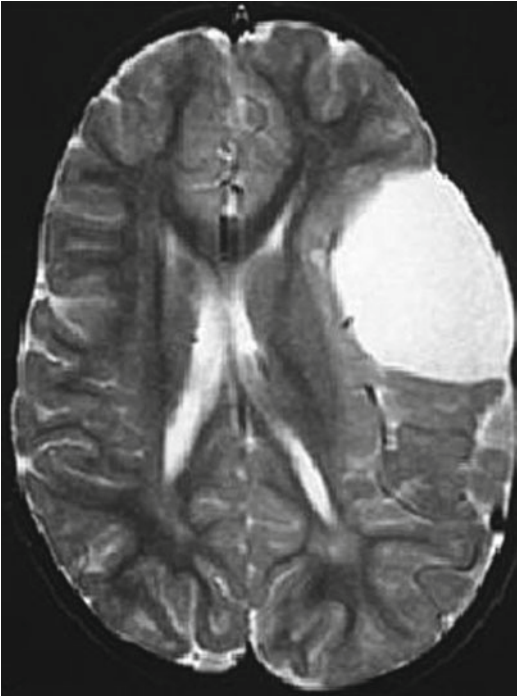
Axial T2w MRI of left medium-size Sylvian cyst inducing a shift of midline cerebral structures with compression and distortion of the ipsilateral ventricle. CSF spaces of the convexity are reduced on the left side compared to the contralateral side. The volume of the left hemicranium is slightly bigger than the right one. The association of the abovementioned signs suggests a mass effect of the lesion
